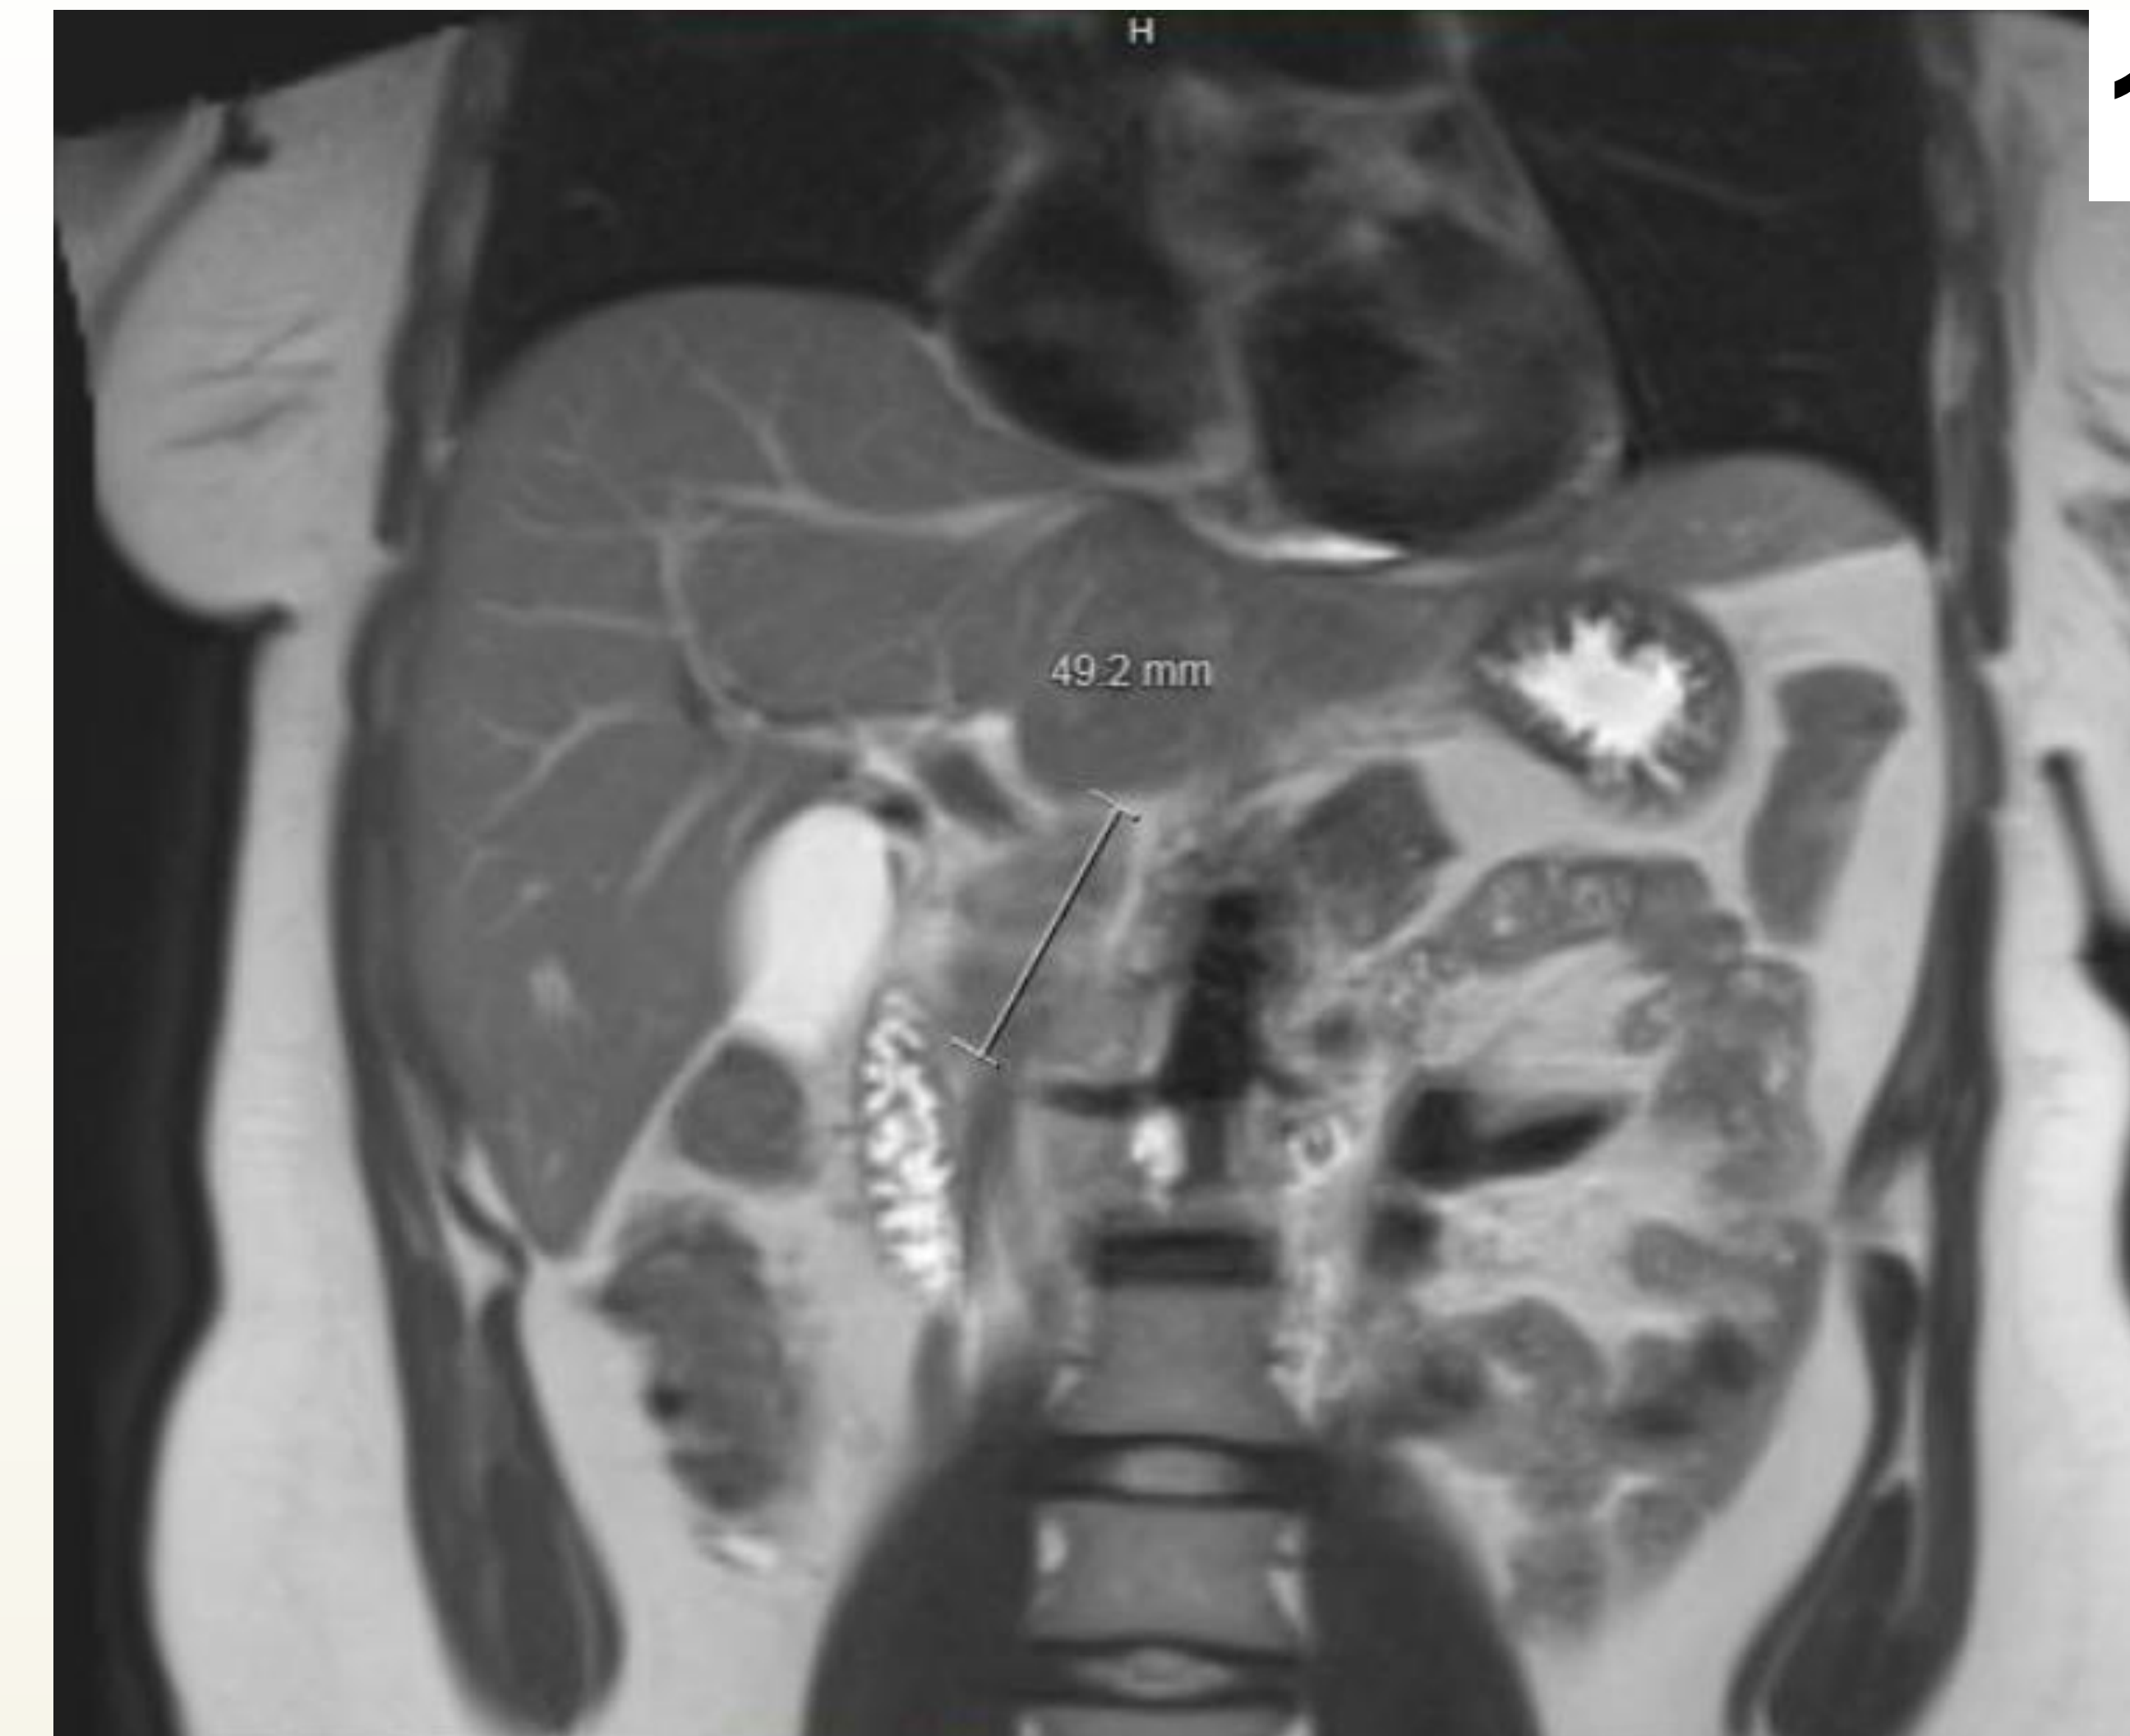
MRI demonstrating 49mm bilobed retroperitoneal mass.
